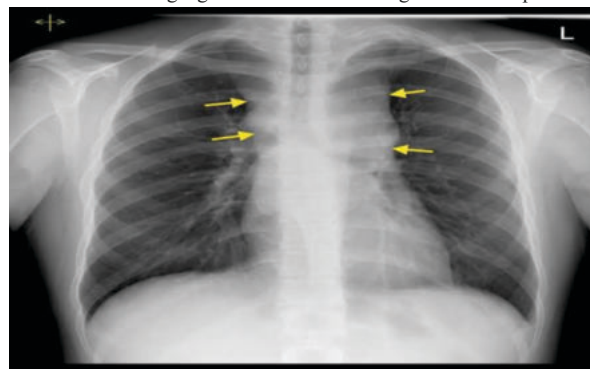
Chest X-ray showing mediastinum widening
